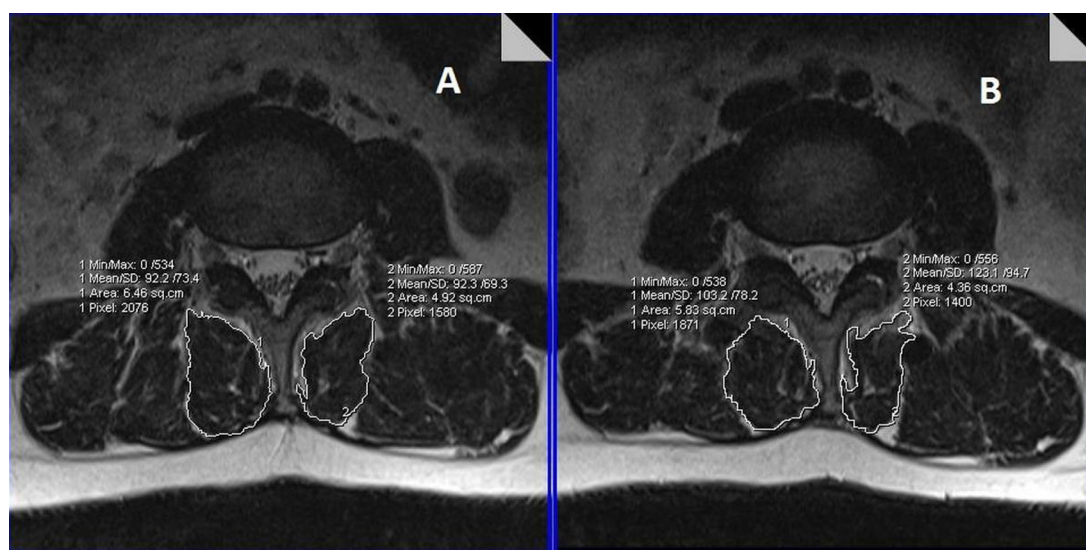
(A, B) Lumbar spinal MRI muscle measurements of pre- and postoperative patients operated on using the Wiltse method.
